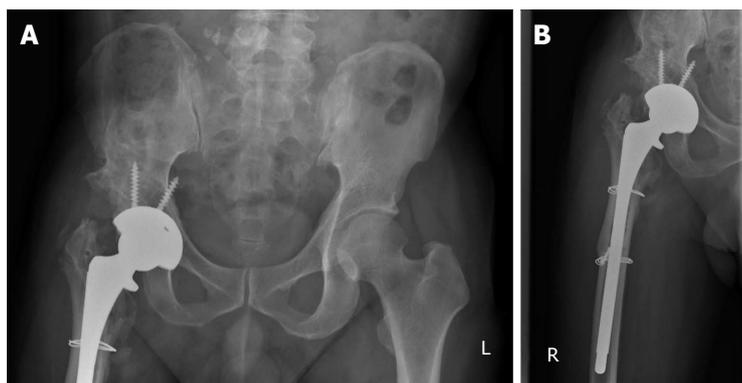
AP (A) and lateral radiographs of the right hip (B) at 4-mo post-operation.
